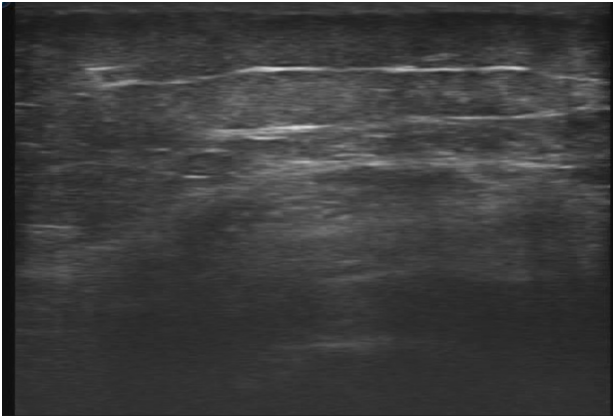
Dynamic ultrasound analysis of thigh muscle of Mr. AC during long-pulse FES x DDM. For the YouTube video link to: https://youtu.be/Gd_f_43GrGg.
